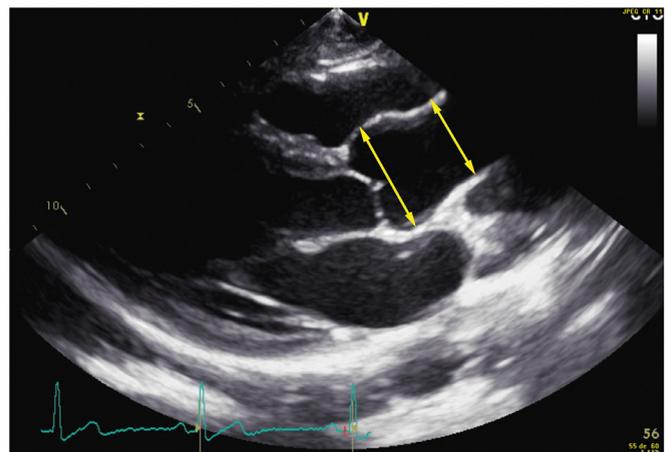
Echocardiographic assessment of aorta diameters (first arrow corresponds to SoV and second arrow to tubular ascending aorta). SoV = Sinuses of Valsalva.
